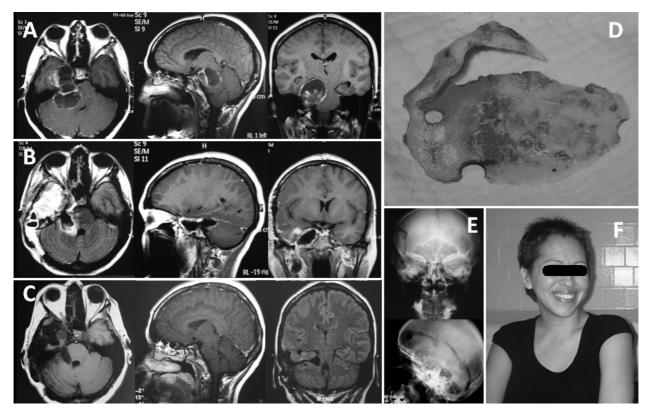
Patient MP, female, 30 years old, with refractory hemifacial pain and corneal hypoesthesia on the right, and mild hemiparesis on the left. (A) Trigeminal "dumbbell-shaped" schwannoma that was operated by the *en bloc OZ-MT* in 2009. (B) First week and (C) five years postoperative follow-up. (D) The *en bloc OZ-MT* bone piece without preserving the whole zygomatic arch. (E) The postoperative X-ray control and (F) the patient after three months postoperative with perfect aesthetic appearance, which is preserved until nowadays, without any complaint or sequel. (Acesso cirúrgico para neurinomas trigeminais. XXI Encontro dos Neurocirurgiões do Brasil Central, Bonito, MS, 2010).
